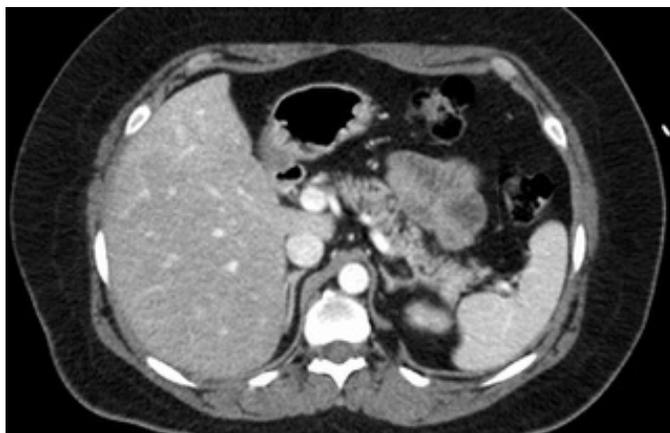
CT of the kidney showing no inflammation or infection after treatment
